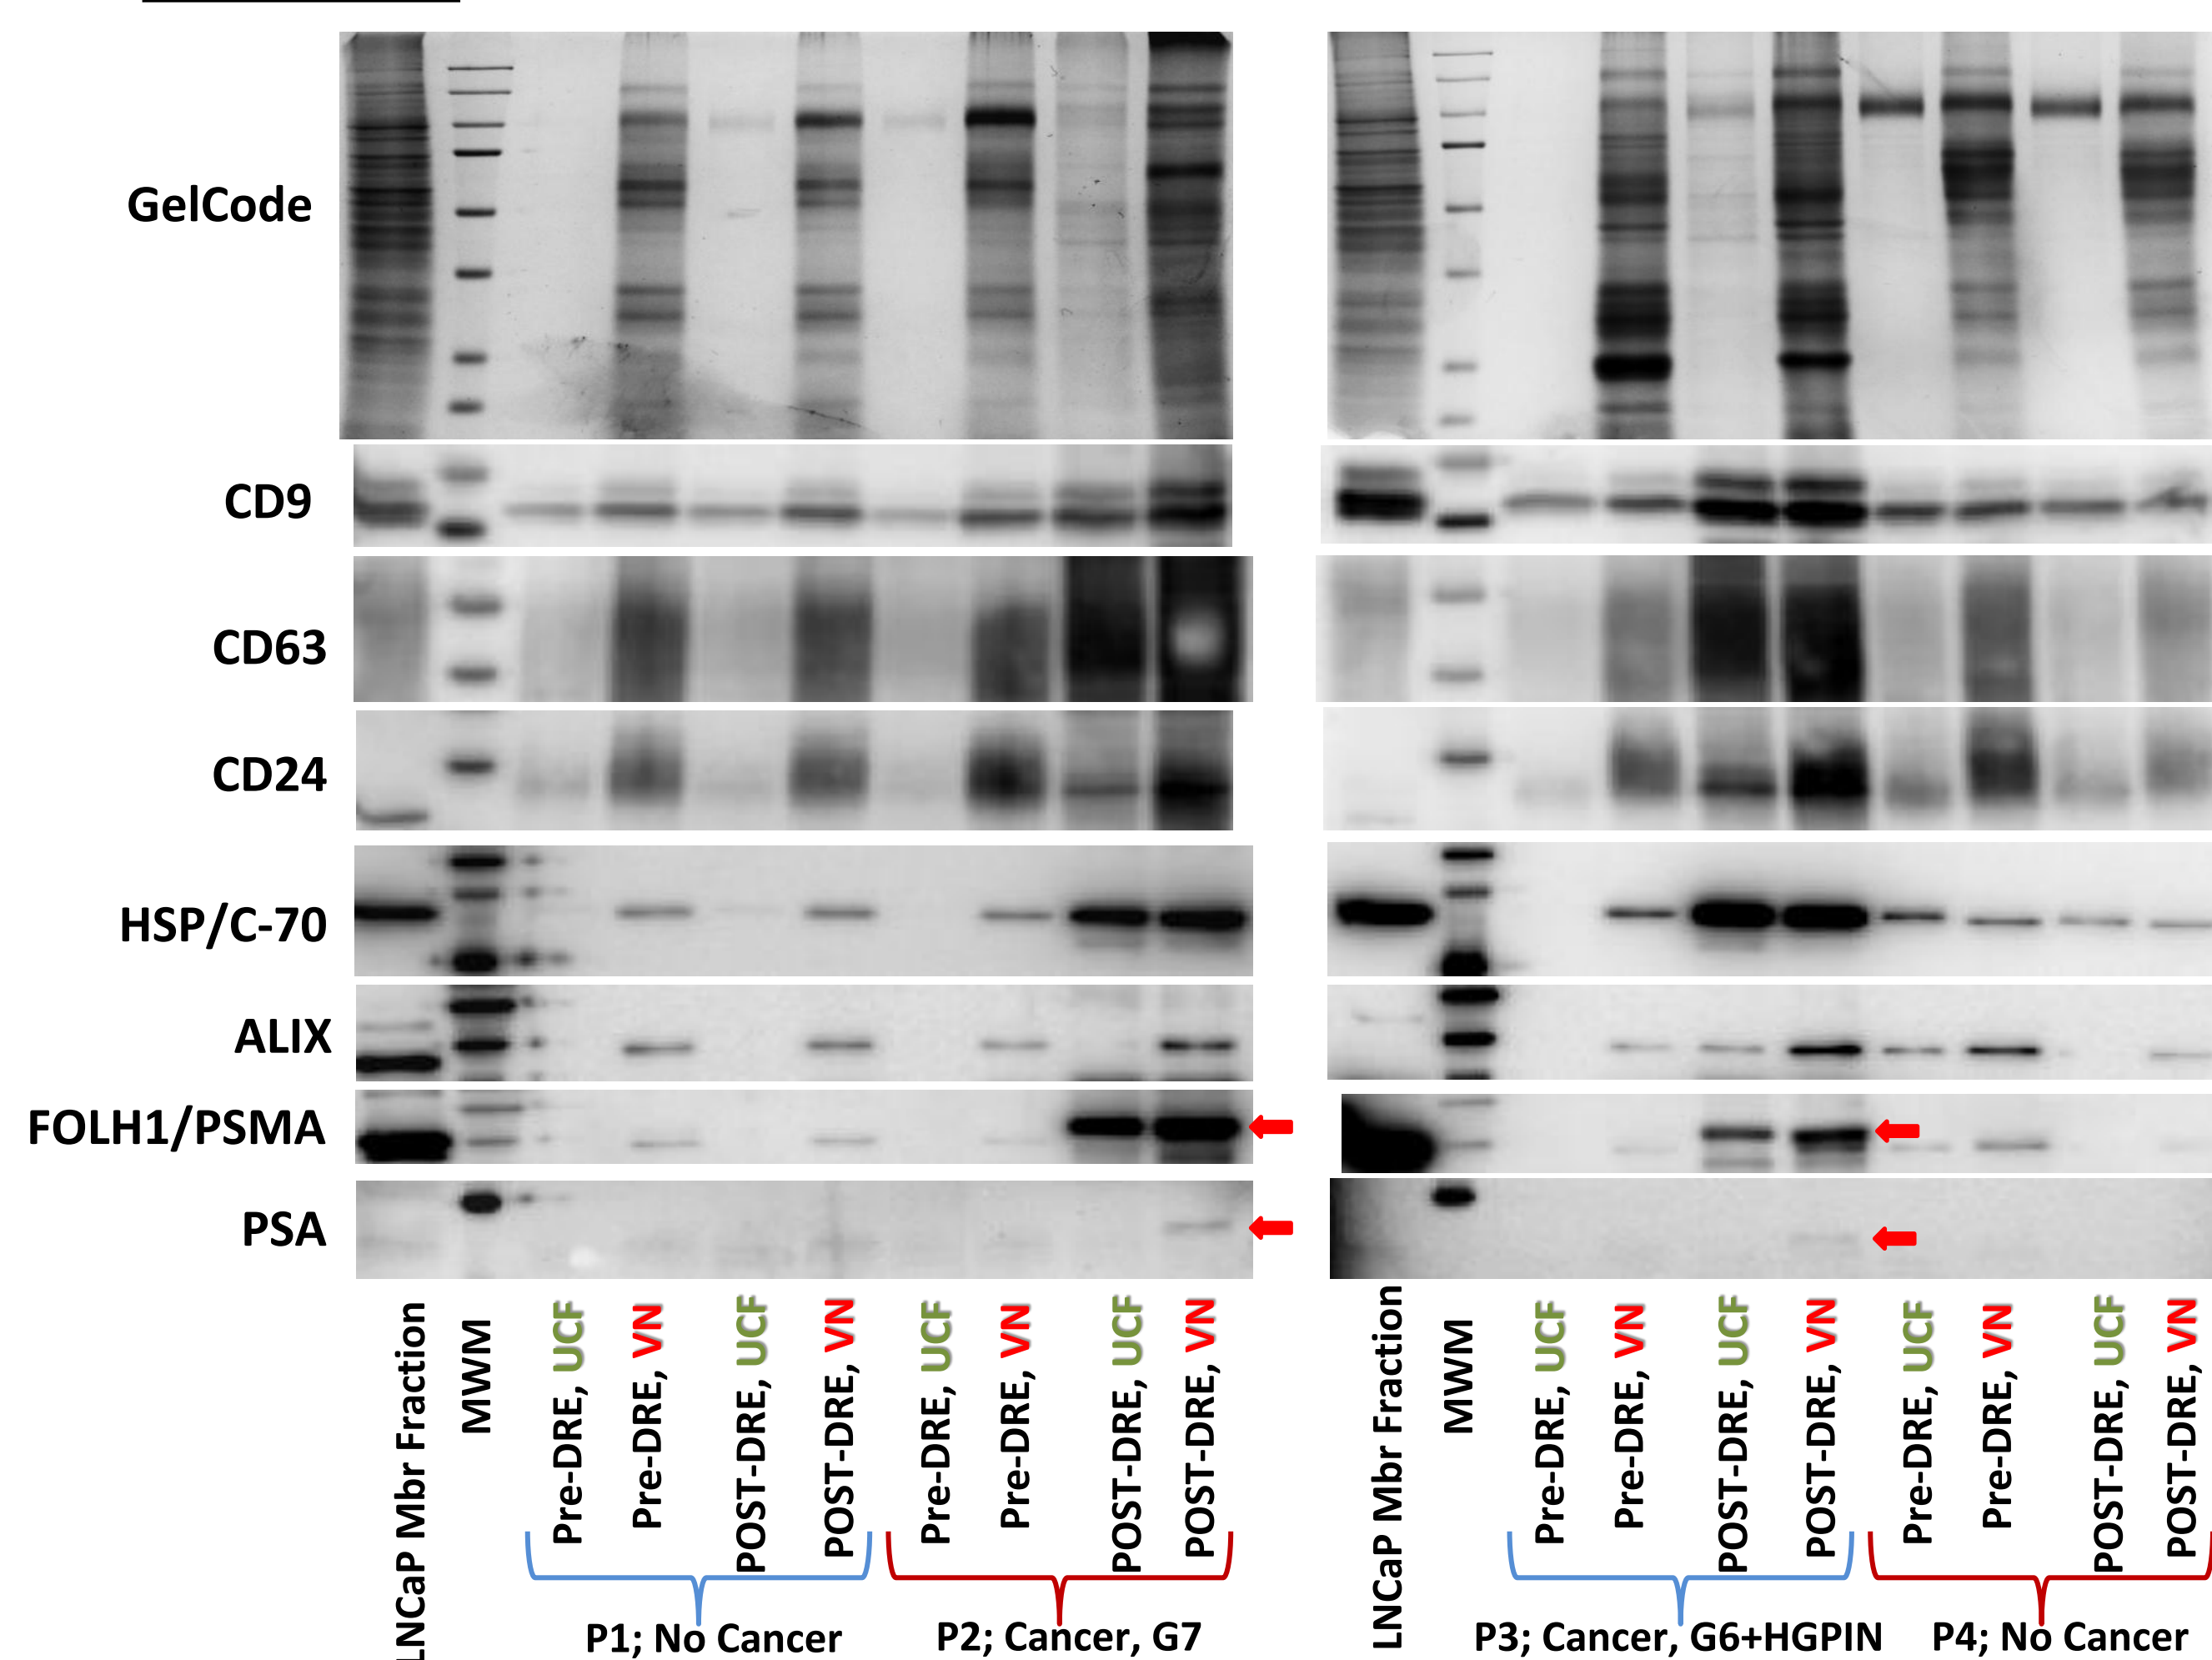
eMV pellets were isolated in parallel from equal volumes of pre- and post-DRE urines using ultracentrifugation and Vn peptide enrichment methods. Urinary Vn-eMV complexes contained canonical vesicle protein markers (CD9, CD63, CD24, HSP-70, ALIX), often in greater abundance than the corresponding UCF eMV fraction. Prostate-specific markers, PSMA and PSA, could be detected in post-DRE Vn urinary eMV's from PCa subjects.
